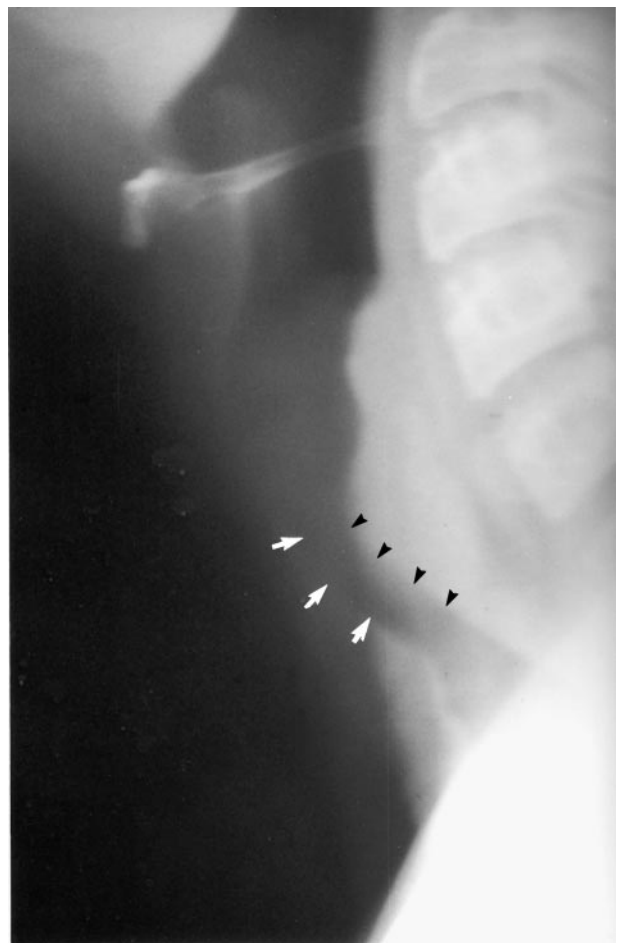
Lateral radiograph demonstrating a foreign body (*arrow*) in the esophagus in a toddler who had been stridorous for several months. The walls of the esophagus and trachea (*double arrow*) are markedly thickened.
